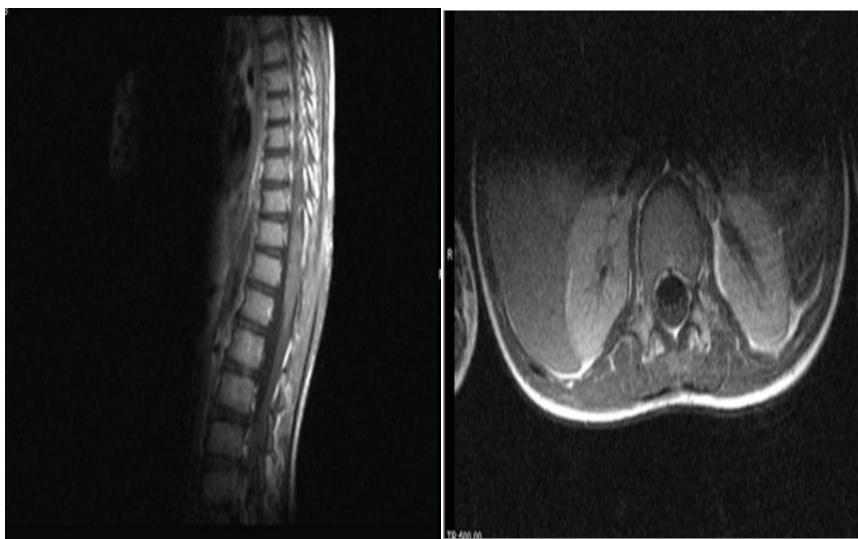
Control thoracolumbar MRI in sagittal and axial sections showing the regression of the inflammation of the cone which returns to its normal appearance
